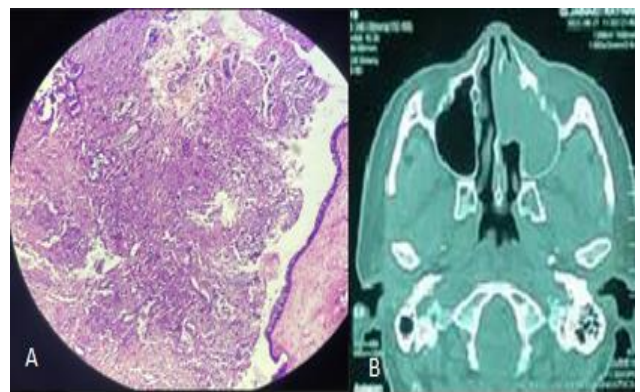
(A and B): HPE and axial CT PNS.
